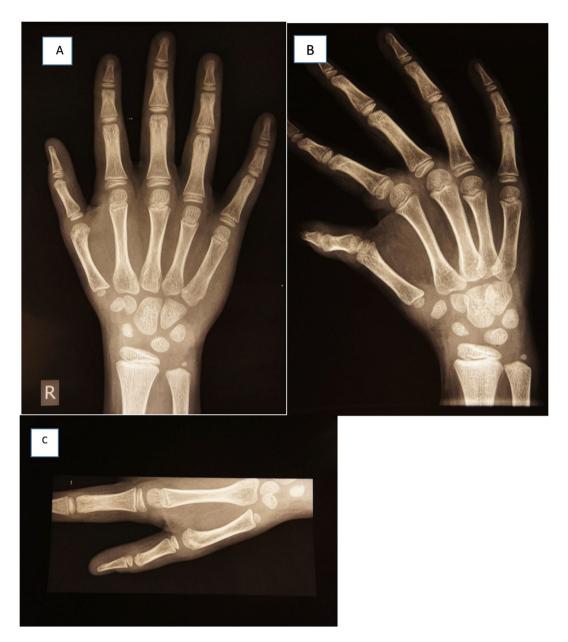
Radiographic evaluation of the the patient shown in Fig. 3. (A) Anteroposterior view, (B) oblique view, and (C) lateral view demonstrating bony deficiency and varying degrees of instability and subluxation at the first MCP joint. However, the first CMC joint appears stable
